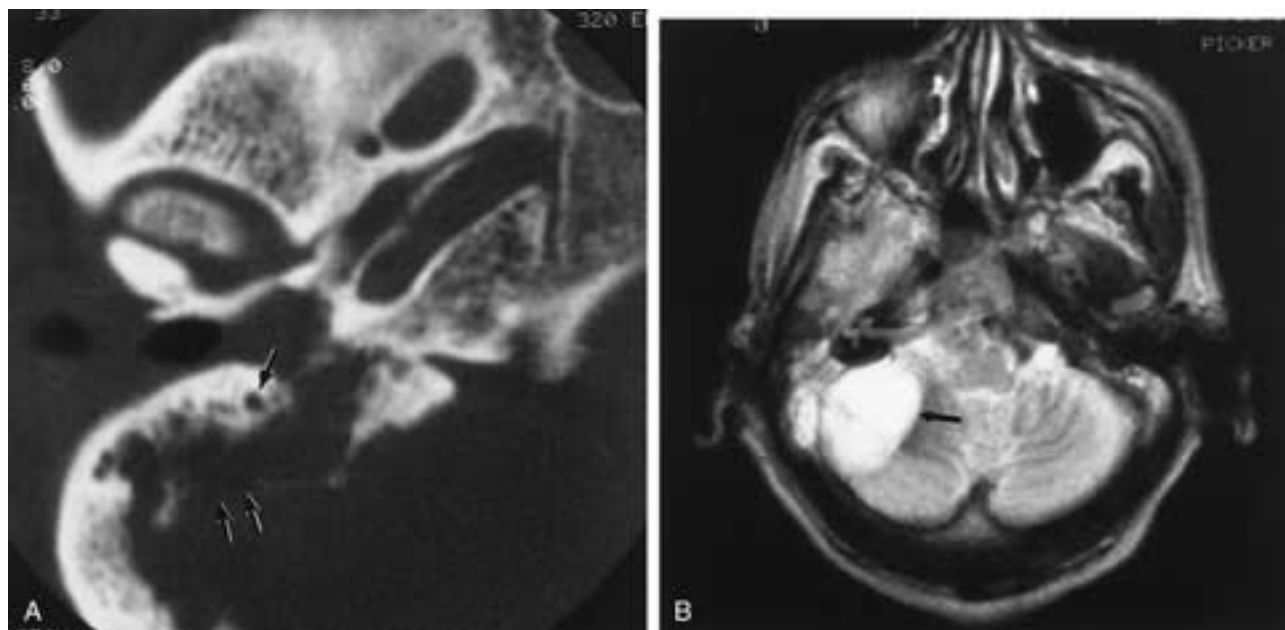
Tuberculous otomastoiditis with cerebellar abscess. A, Axial CT, right ear. Diffuse destruction of internal mastoid cortex (*double arrows*) associated with middle ear and mastoid debris. Single arrow, facial nerve. B, Large, hyperintense mass seen on T2-weighted MR image. Abscess confirmed at surgery.
